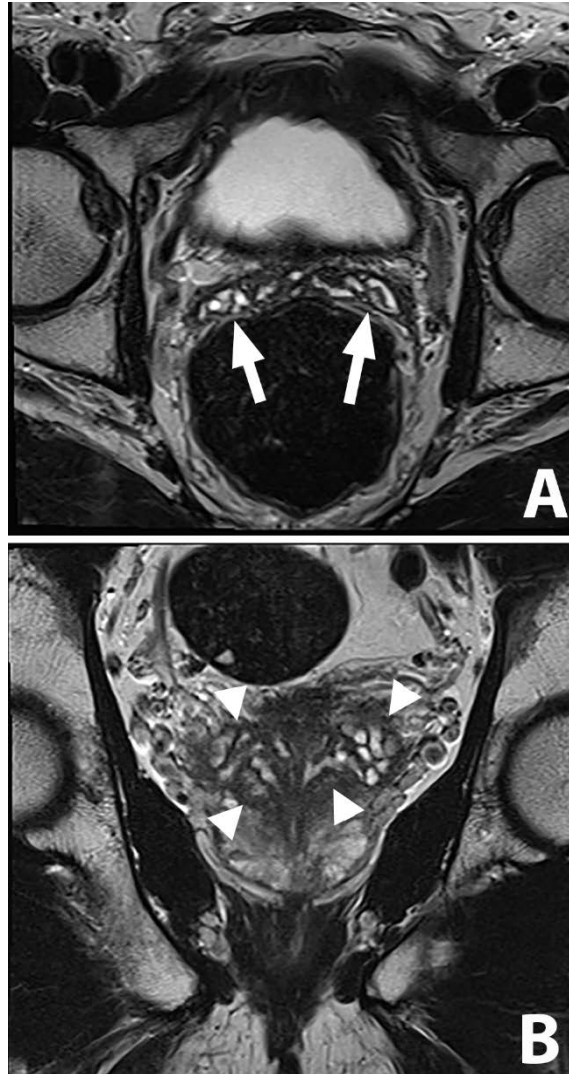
MR imaging appearance of normal seminal vesicles. Figure 2A. Axial T2-weighted image demonstrating tubular structures (arrows) with septae, representing normal seminal vesicles, posterior to the urine-filled bladder. Figure 2B. Coronal T2-weighted image showing seminal vesicles (arrowheads). Prostate gland is partly visualized inferior to the seminal vesicles.
